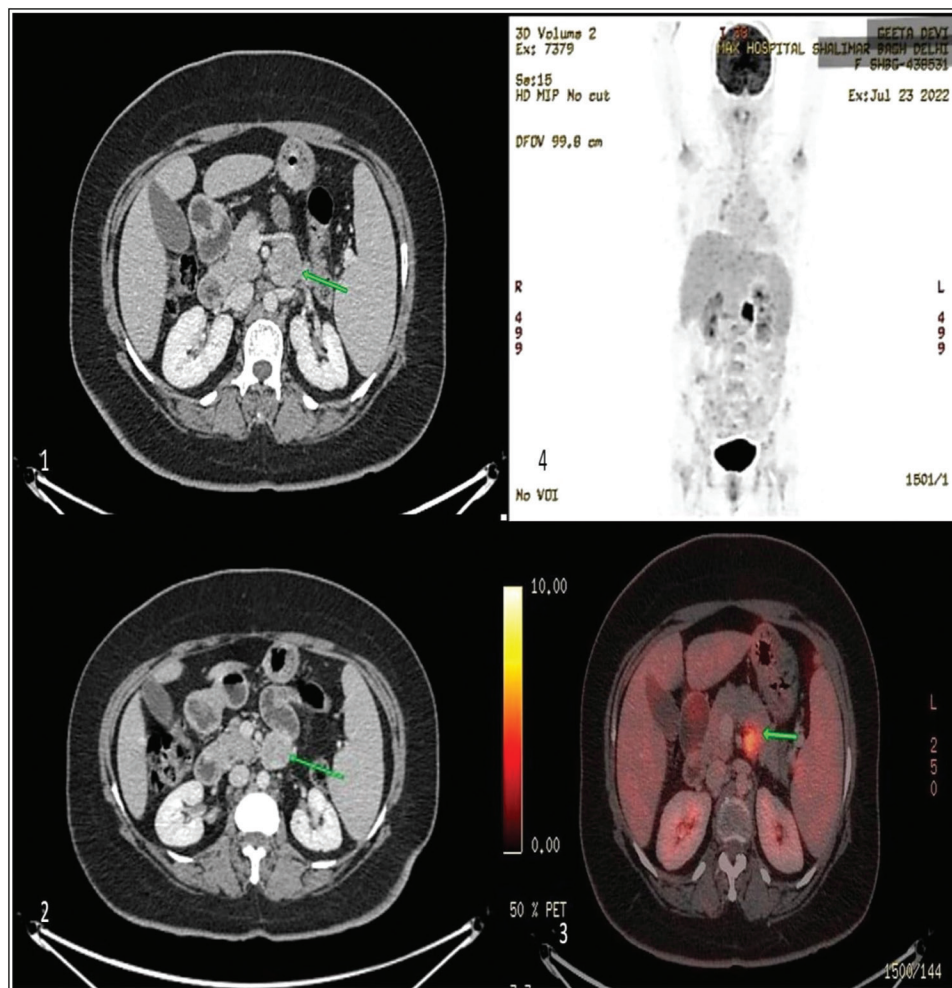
(Anticlockwise from top left) (1, 2): Cross-sectional image of contrast-enhanced CT scan showing a mass (*thin green arrow*) arising from D3 to D4 abutting the pancreas but with preserved fat planes with surrounding major vasculature. (3): PET-CT in axial plane showing the same mass with florid fluorodeoxyglucose uptake (standard uptake value = 10). (4): Fluorodeoxyglucose-PET image in coronal section showing area of increased uptake at the tumour site, with brain and bladder acting as reservoir organs
